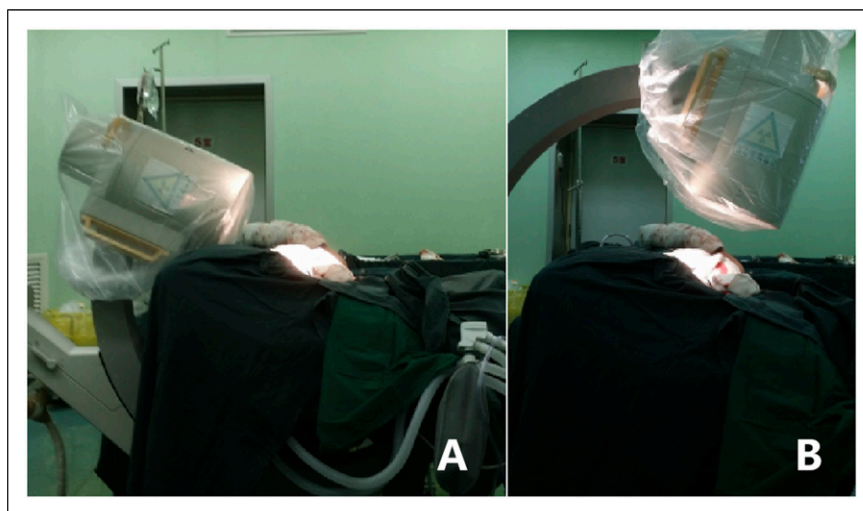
C-arm X-ray contralateral directions based on the LTS position during surgeries. For AP view X-ray (A); For lateral view X-ray (B).
